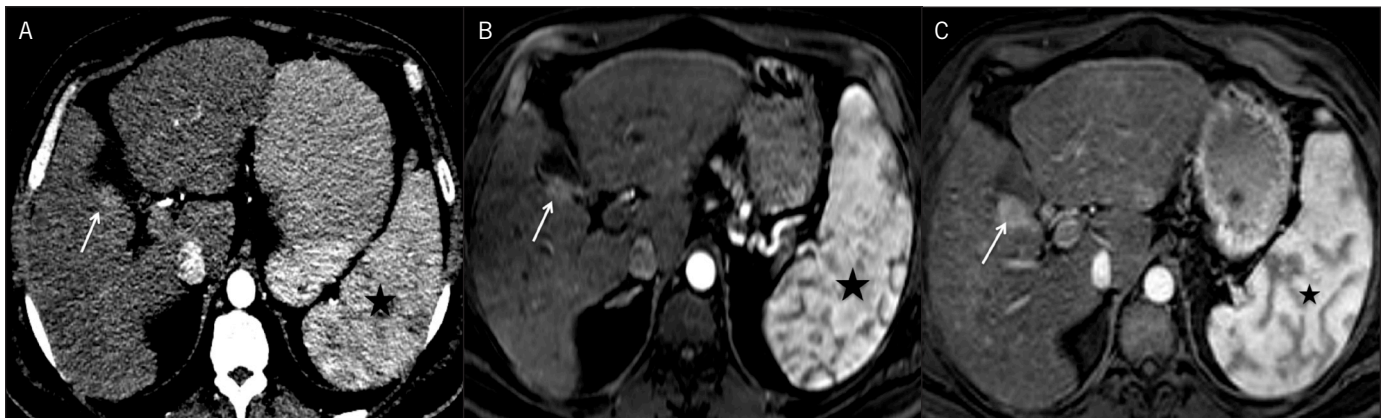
(A) Arterial phase contrast-enhanced CT image showing a faint area of arterialization (arrow) in the segment V of liver adjacent to the GB fossa, irregular liver outline, and splenomegaly (star). Arterial phase MRI images (B) at presentation and (C) at 3-month follow-up confirm the enlargement of a small arterially enhancing lesion in the right lobe (arrow).
